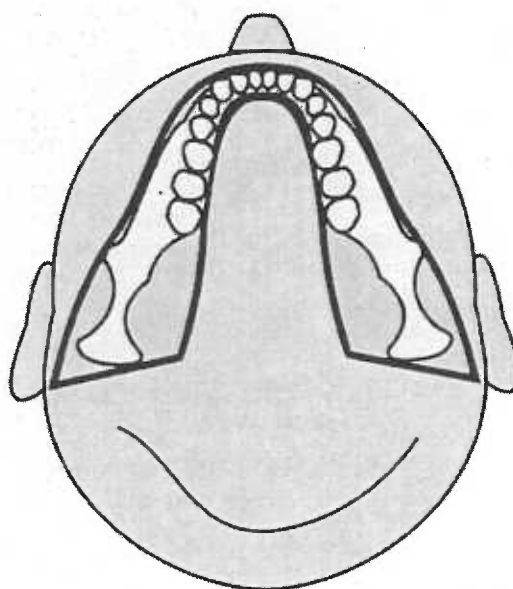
Focal trough shape of Orthopantomograph OP 100 (Orthopantomograph OP 100 instructions manual)
